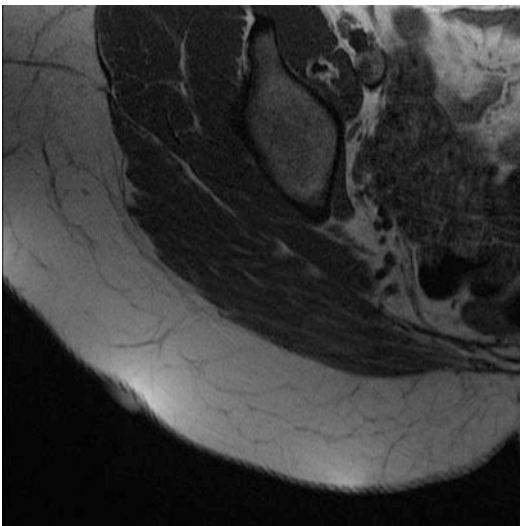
MRI image of the buttock showing a skin marker on a depressed lesion of cellulite and its correspondent fibrous septa. MRI can be also used to study fat tissue in areas with cellulite
